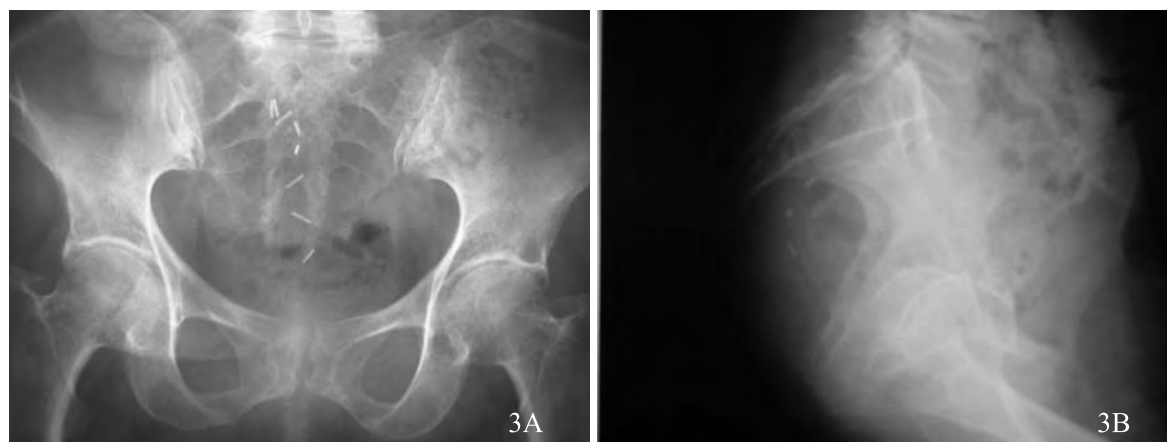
X-ray of abdomen after LAPA with LPP.
